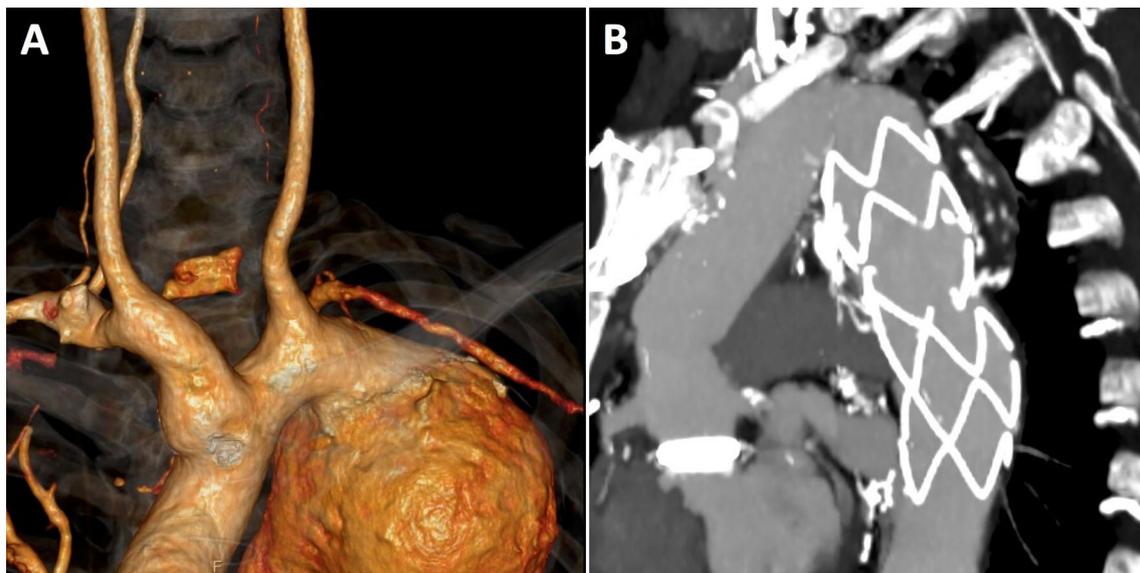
Angio-CT showing a degenerative distal aortic arch aneurysm: a before and b after the E-vita hybrid graft implantation
